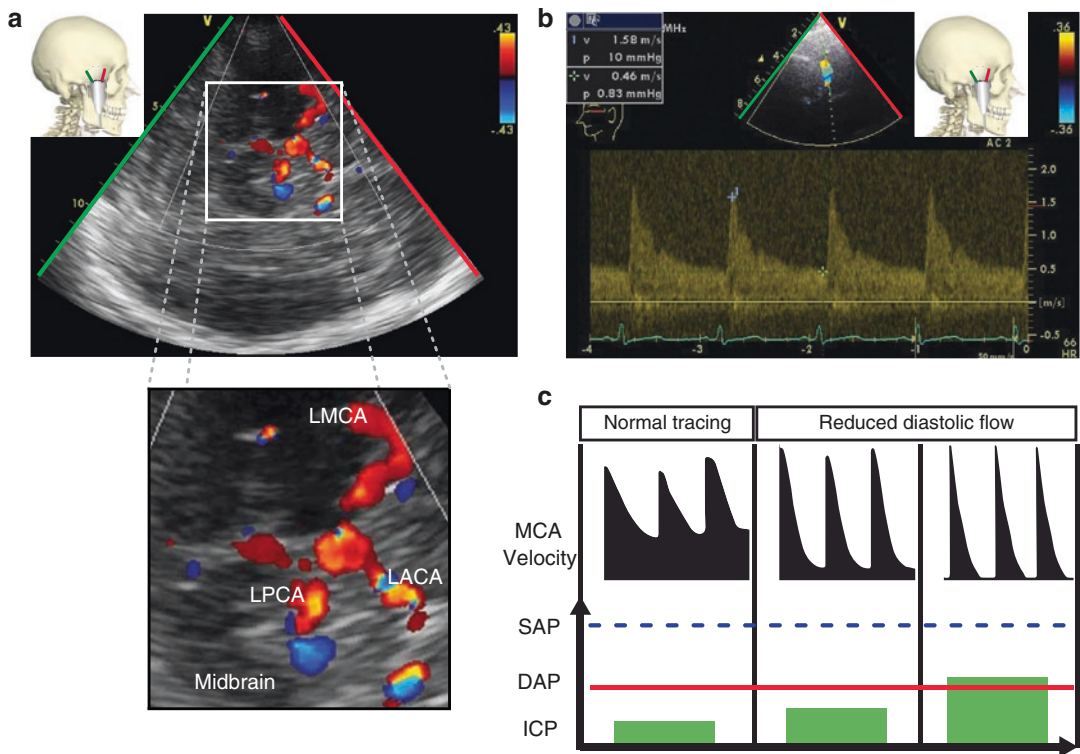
Transcranial Doppler color-coded duplex sonography. The middle cerebral artery (MCA) is interrogated using a transthoracic probe positioned over the right temporal region. (a) A 2D image of the circle of Willis with color Doppler (Nyquist 43 cm/s) where flow interrogation is obtained. (b) Sample volume positioning in the vessel allows precise determination of the MCA velocity spectral Doppler
